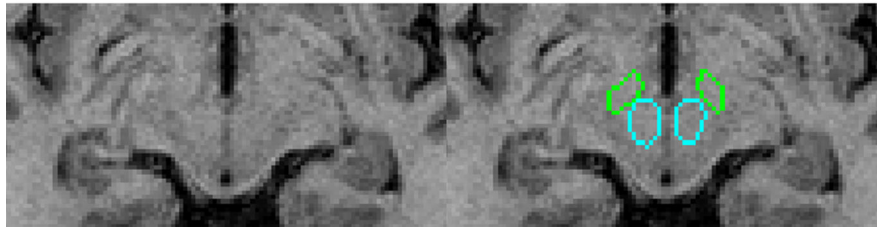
Examples of hyperintense globus pallidus (yellow), caudate (red, reference area), and central medial nucleus (cyan) (A), dentate nucleus (yellow) and juxta-dentate white matter (red) (B), and substantia nigra (green) and red nuclei (cyan) (C), overlaid on T1-weighted precontrast scans
